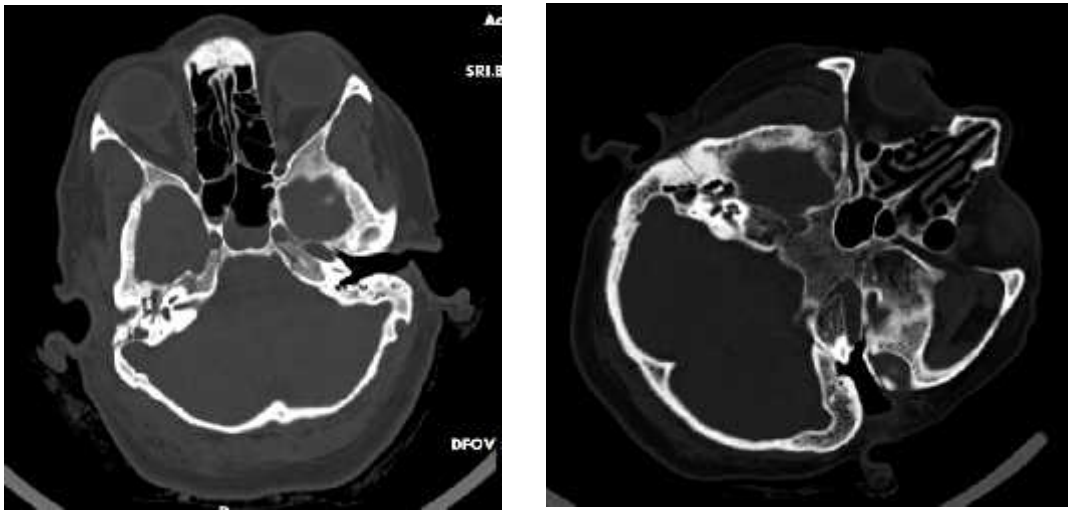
2 cases in CT axial bone window showing fracture line involving petrous and mastoid parts of right temporal bone with the fracture line being parallel to that of petrous ridge suggestive of longitudinal fractures. There was blood density collection noted within the middle and external ear. Ossicular chain appears intact in both cases.
